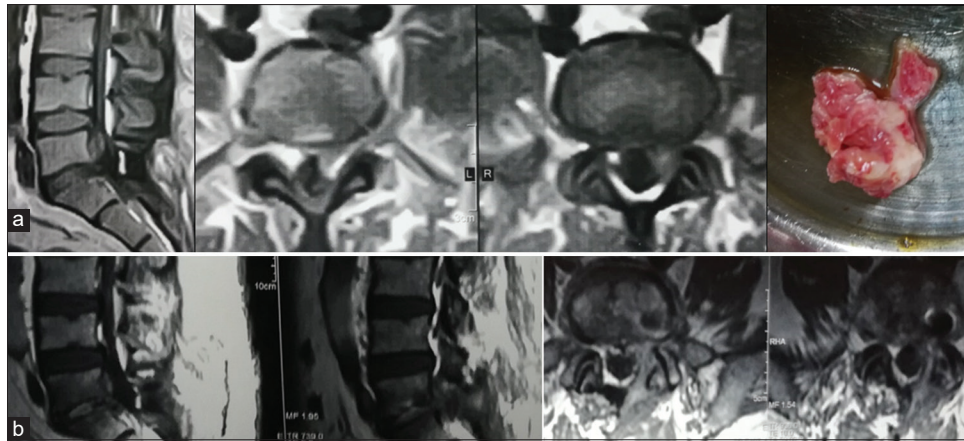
(a) MRI at presentation with old L5 laminectomy and L4 partial laminectomy and above levels stenosis. (b) MRI follow-up after deterioration shows deep wound infection and epidural collection.
